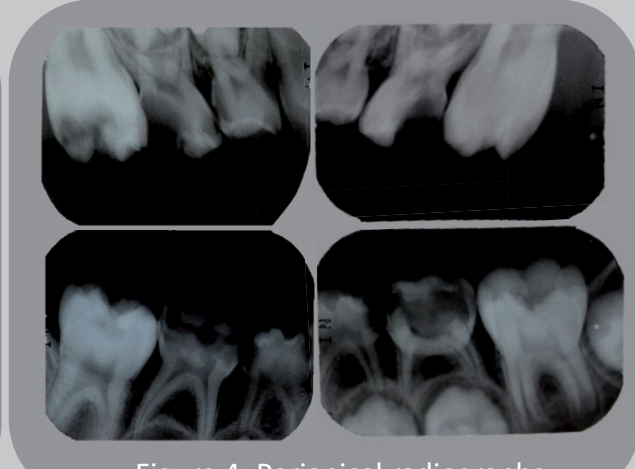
Periapical radiographs
